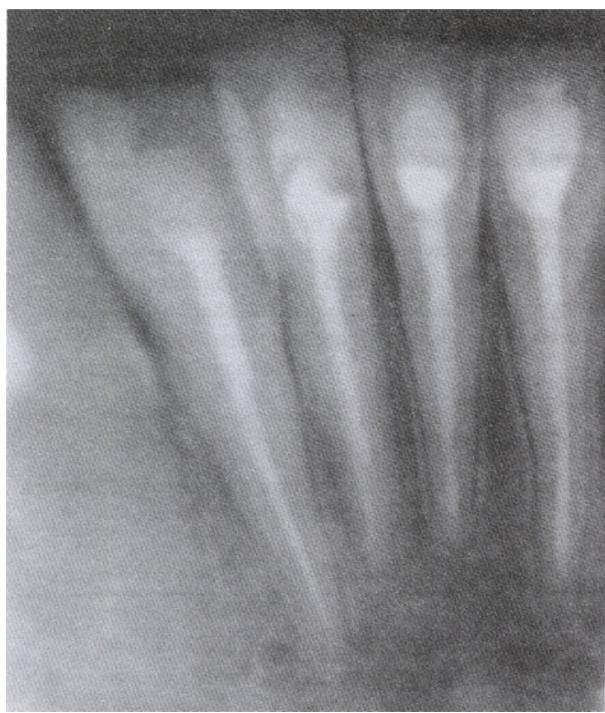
The radiographic evaluation of case at the end of 3 years.
